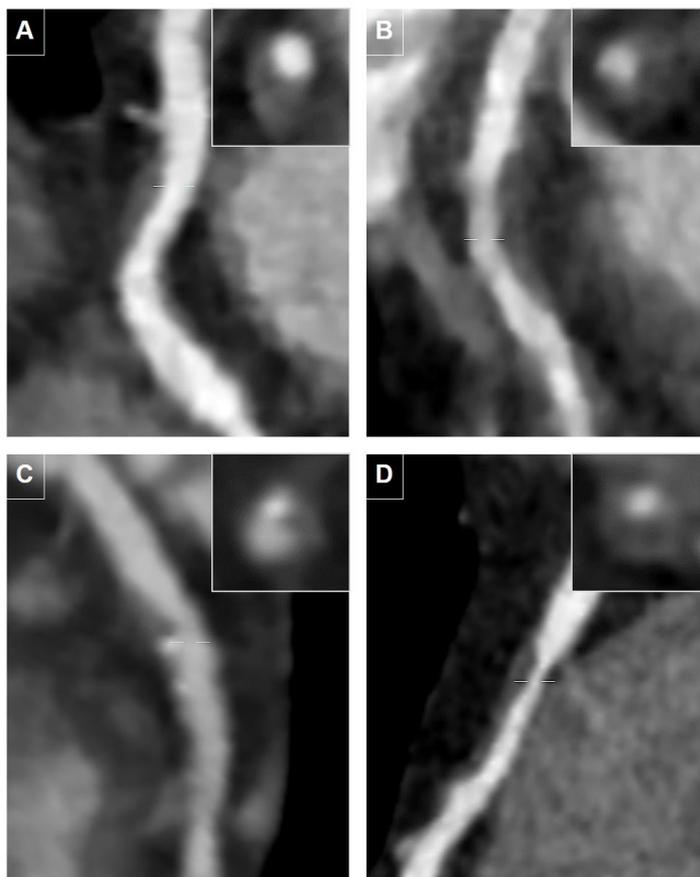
Plaque characteristics assessed by coronary computed tomography angiography
